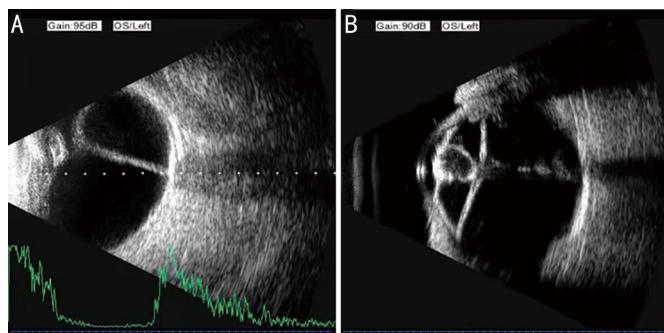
Case of difficult diagnosis of retinal detachment A: Conventional B-ultrasound image; B Pano-immersion B-scan ultrasound imaging diagnosis of retinal detachment with abnormal lens shape.
